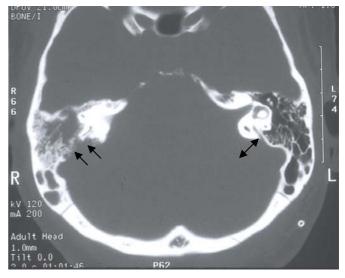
Axial CT scan shows destruction of left vestibular aqueduct as well as erosion of right petromastoid plate (arrows). Note normal left vestibular aqueduct (double-headed arrow).
